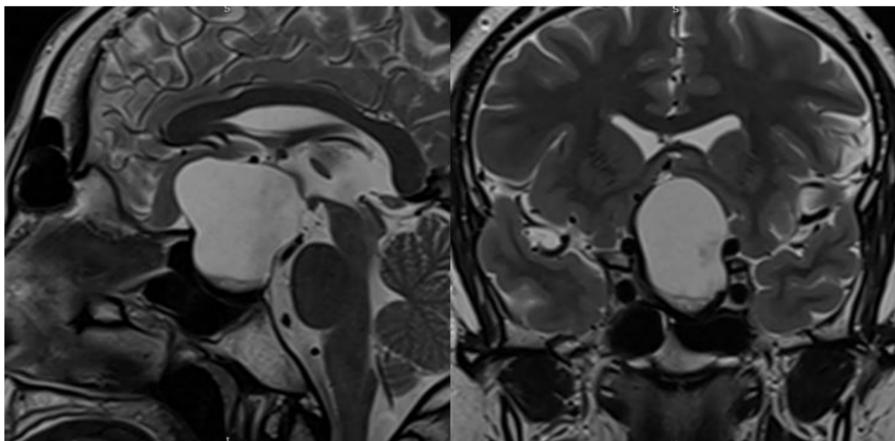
First case - Magnetic resonance imaging of patient 1 showing in sagittal (A) and coronal (B) views a large, predominantly cystic lesion hyperintense on T2, with a small solid hypointense component on T2, exhibiting mass effect and compression of adjacent structure, including the optic chiasm and the anterior communicating complex.
